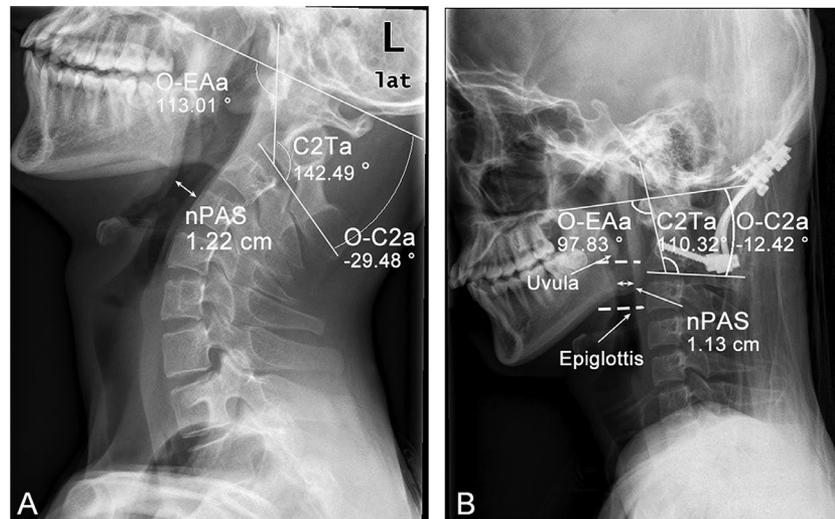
Representation of radiographic measurements. O-EAa is defined as the angle formed by McGregor's line and the line connecting the external acoustic meatus to the midpoint of the caudal endplate of C2. C2Ta is defined as the angle formed by the inferior endplate of C2 and a line connecting the external acoustic meatus with the midpoint of the caudal endplate of C2. O-C2a is defined as the angle formed by McGregor's line and a line extending through the caudal endplate of C2. nPAS is defined as the narrowest anteroposterior distance from the posterior pharyngeal wall to the back of the tongue, between the tip of the uvula and the tip of the epiglottis. In this case, the preoperative (A) and postoperative (B) values of O-EAa were 113.01° and 97.83°, those of O-C2a were -29.48° and -12.42°, those of C2Ta were 142.49° and 110.32°, those of nPAS were 1.22 cm and 1.13 cm, respectively.
